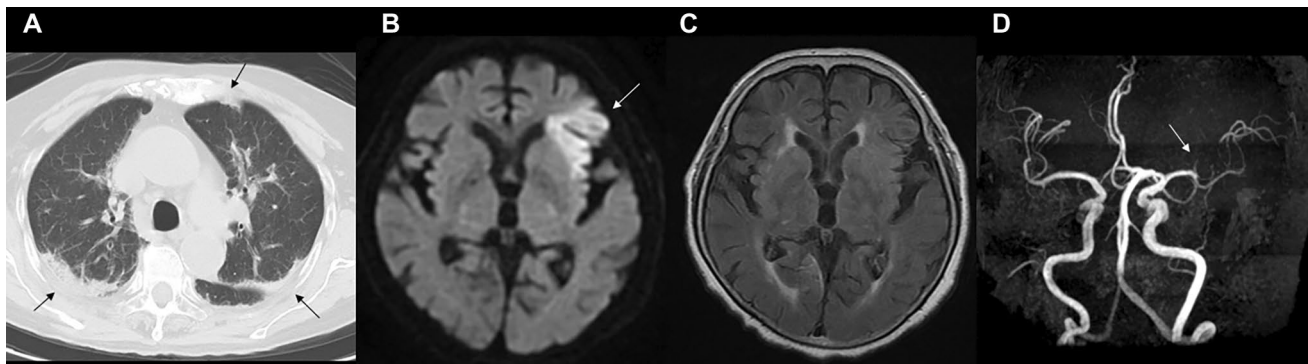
Imaging data of the patient. A Chest computed tomography showed multiple peripheral-dominant bands of shadows in the bilateral lower lung fields, which were considered to be changes after COVID-19 pneumonia. B Head magnetic resonance imaging revealed
